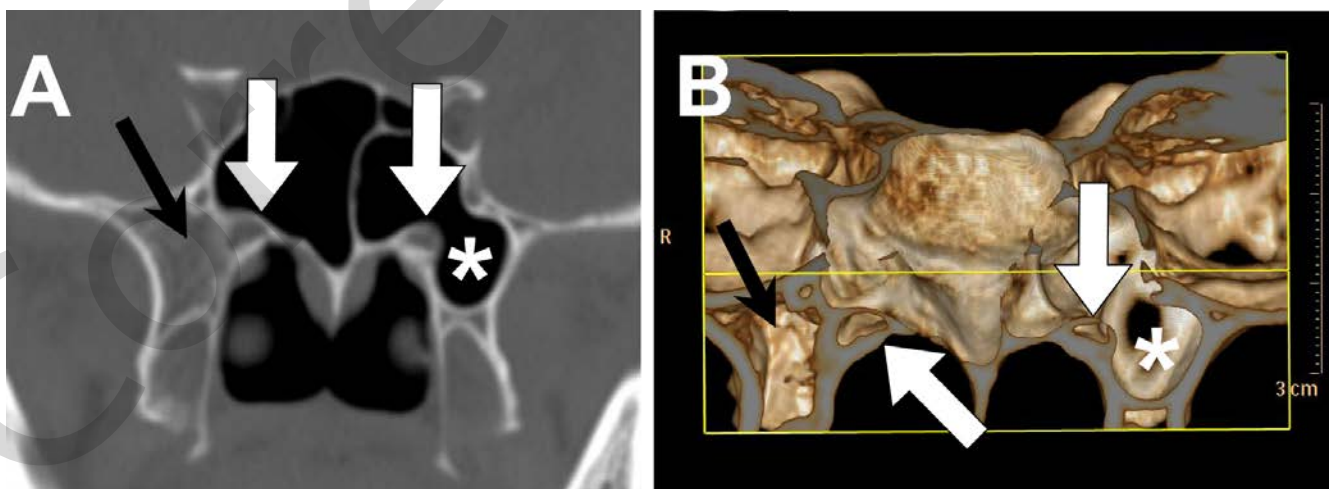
The coronal CT slice (A) and 3D reconstruction image (B) delineate the variation of pterygoid process pneumatization (pterygoid recess, PR). The PR is present on the left side (asterisk) but absent on the right side (black arrow). Bilateral vidian canal protrusion (white arrow) is also demonstrated.
